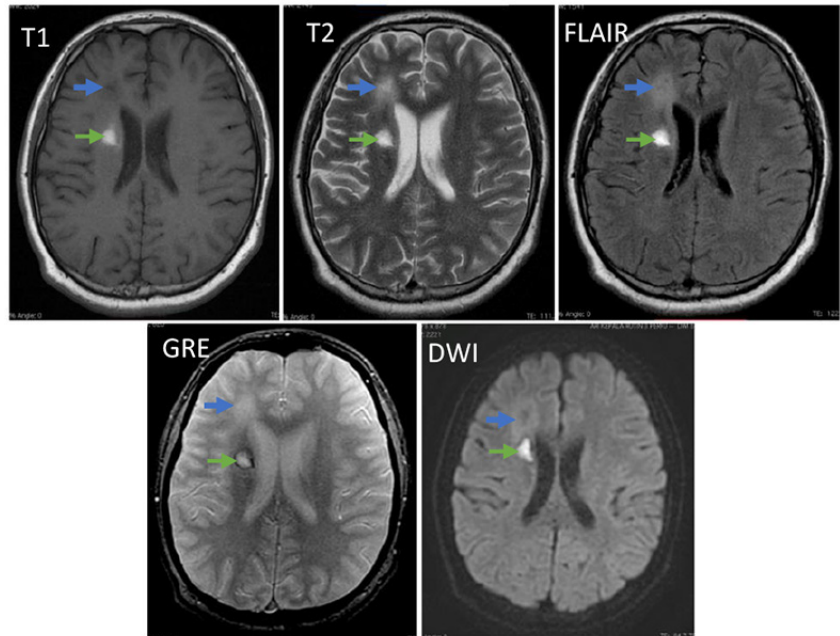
Head MRI results show bleeding in the corona radiata area to the right thalamus (green arrow) and cerebral infarction in the right frontal lobe cortex-subcortex area (blue arrow).
